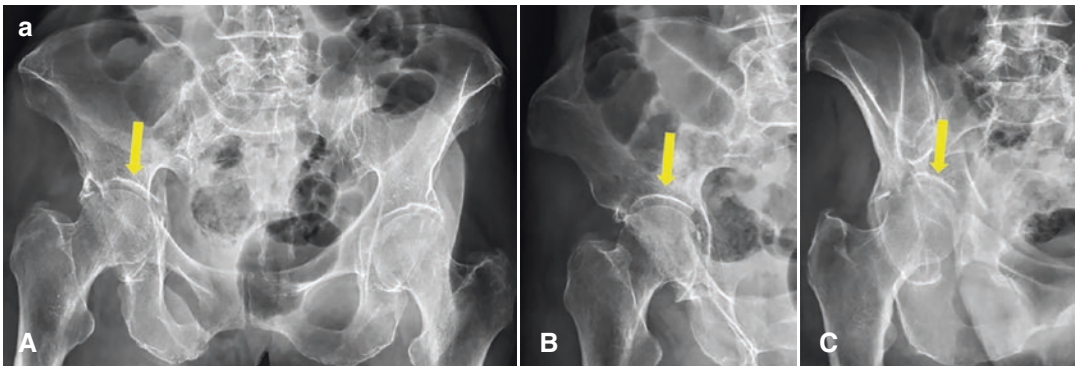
(a) Preoperative radiographs with (A) anteroposterior, (B) iliac oblique, and (C) obturator oblique views showing an acetabular fracture (anterior column/ posterior hemitransverse) in a 74-year-old female patient with dome impaction (yellow arrow), breakout of the quadrilateral plate and intrapelvic protrusion of the femoral head. (b) Preoperative CT scans with (A) axial (dome level), (B) coronal, and (C) sagittal reconstruction planes showing the acetabular fracture (anterior column/posterior hemitransverse) of the same patient. (c) Postoperative radiographs with (A) anteroposterior, (B) iliac oblique, and (C) obturator oblique
